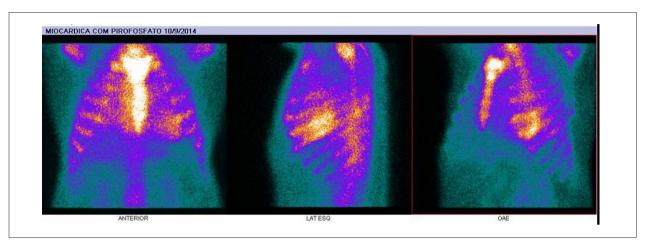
99m Tc-pyrophosphate myocardial scintigraphy: planar images of the chest showing high uptake in cardiac basal lateral segment, suggestive of acute myocardial infarction in healing stage.
